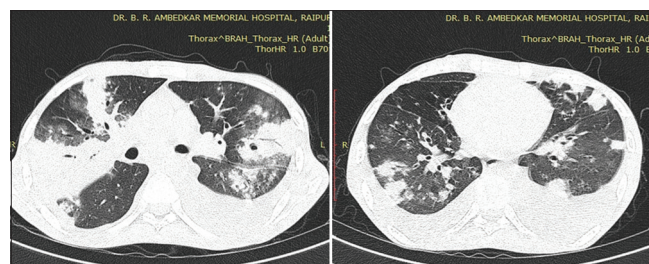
Axial HRCT scan showing the patchy area of airspace consolidation in subpleural in location. Surrounding ground-glass opacity can be clearly seen. Few ill-defined nodules are also noted. Case of bronchiolitis obliterans organizing pneumonia
